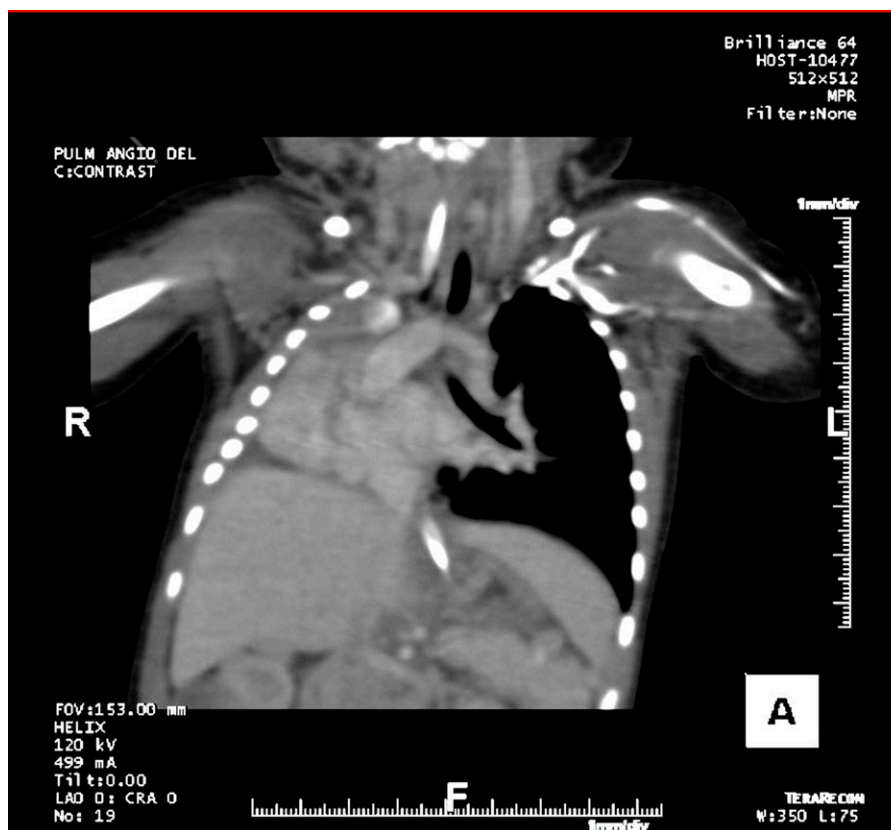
CT scan of the chest showing lung aplasia.
